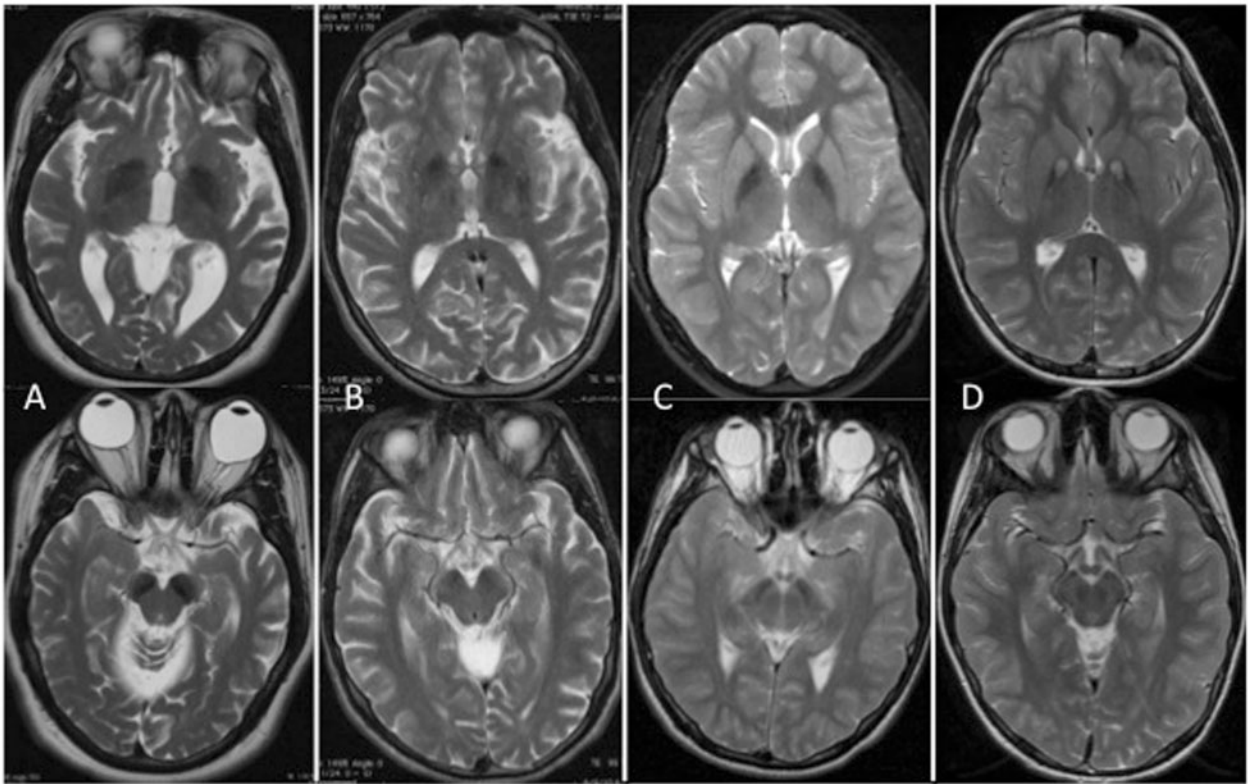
MRI of the globus pallidus and substantia nigra in four main forms of NBIA. Axial T₂-weighted imaging of globus pallidus (*top* series) and substantia nigra (*bottom* series) in (A) BPAN; (B) phospholipase A2-associated neurodegeneration; (C) mitochondrial membrane protein-associated neurodegeneration; and (D) pantothenate kinase-associated neurodegeneration.
